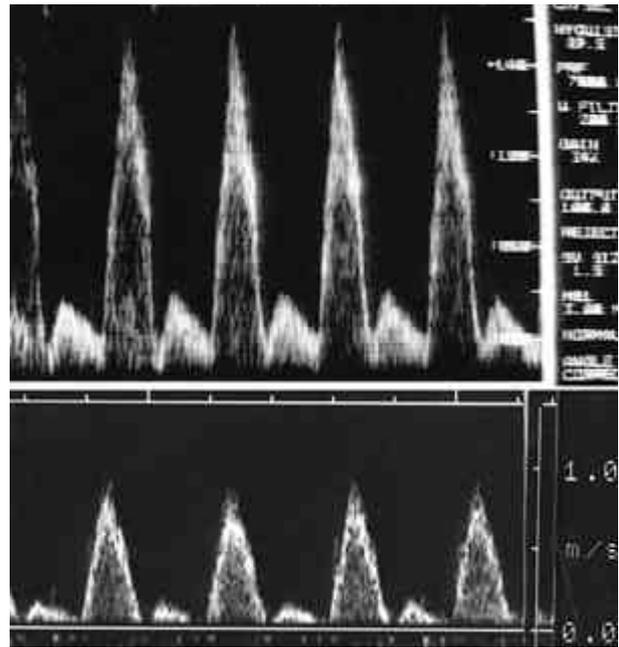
Doppler waveforms of ductus arteriosus. Upper panel shows more common pattern of flow, in which the diastolic peak begins to rise before the previous systolic peak returns to baseline. Lower panel shows two separate peaks.
